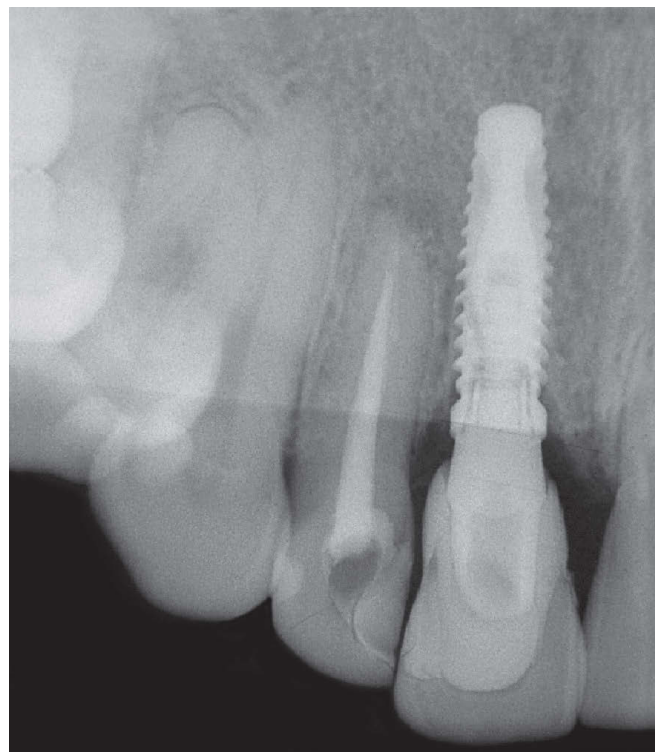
Periapical control radiograph at 90 days after implant placement.
